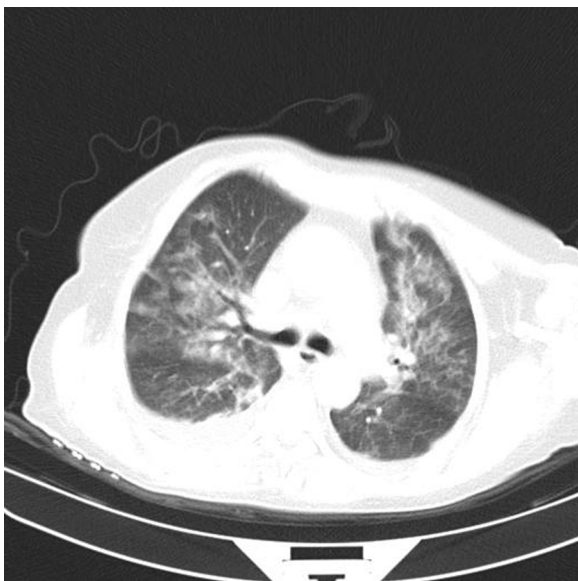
Thorax computed tomography showing pneumonia.
